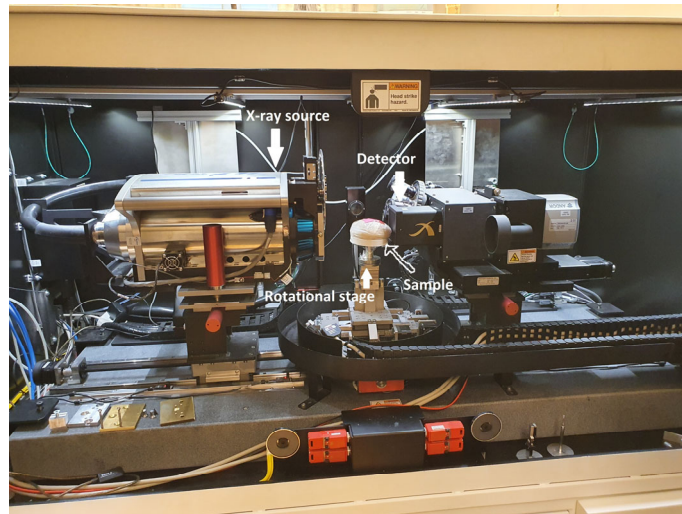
Set-up of lab-based X-ray microtomographic analyses of buns.
